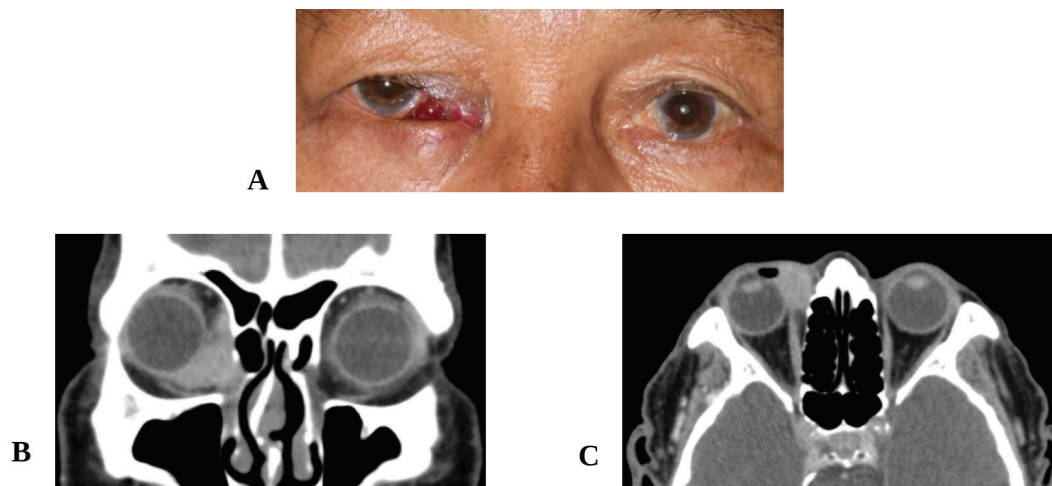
69-year-old Thai male with right medial canthal mass (A). CT-scan of the orbits: coronal (B) and axial (C) views. A large mass presents in the area of the lacrimal sac extending to the nasolacrimal duct with superotemporal displacement of the right globe. (B) The mass involves the insertion of the right medial rectus muscle (C)
